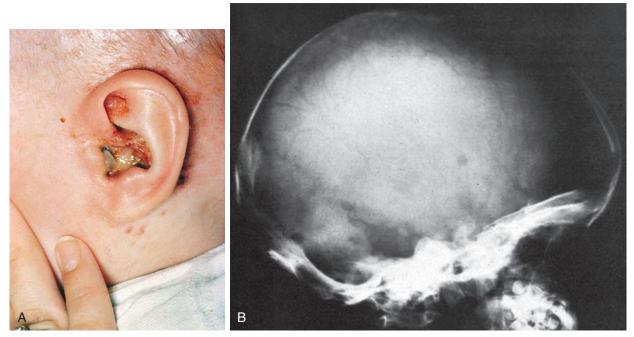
A, Otorrhea in a child with Langerhans cell histiocytosis. B, X-ray film showing destruction of the mastoid bone in the same child. (A, Courtesy P. Gaffney, MD, Pittsburgh, Pa.)
